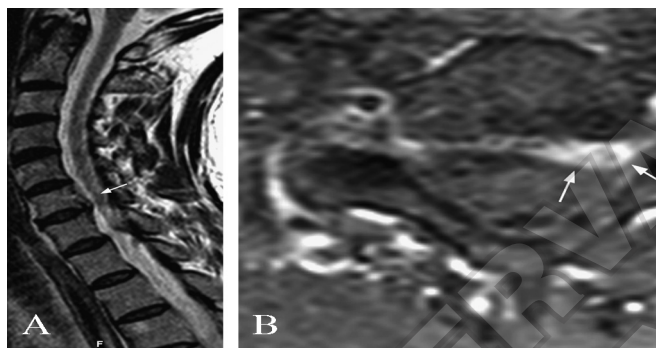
A) Follow-up T2-weighted sagittal image after two months shows prominent regression in the mass like appearance of the sequestered disc in the subarachnoid space (arrow); B) two months later follow-up contrast enhanced T1-weighted axial image represents almost total resorption of the sequestered fragment (arrow).
